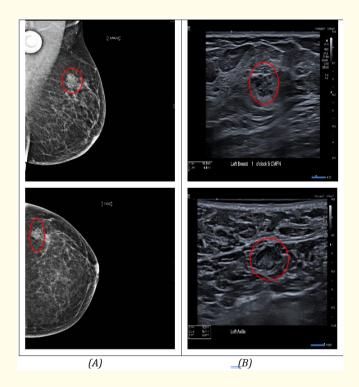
(A) MLO and CC views of mammogram showing focal asymmetry at the upper outer quadrant, of the left breast, suspicious for malignancy. (B) Ultrasound of the left breast showing a 1 x 0.7 cm irregular shape heterogeneous mass at 1 o'clock, that is highly suspicious for malignancy (BIRADS 5) and a left axillary lymph node with a borderline thickened cortex.
